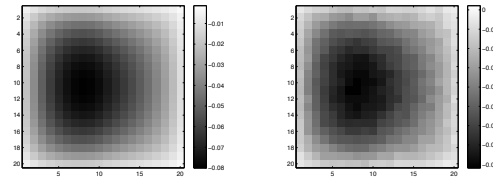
2D cross section in the horizontal plane of the 3D computed MRI phase for the conductivity setup shown in Figure 1. As expected the computed phase has a higher curvature corresponding to the more conductive region, as here the Laplacian takes a larger value compared to the less conducting region. The units used for plotting the phase are radians, and the range is -0.08 to 0.00 radians. ADD COMMENTS for noisy phase.
